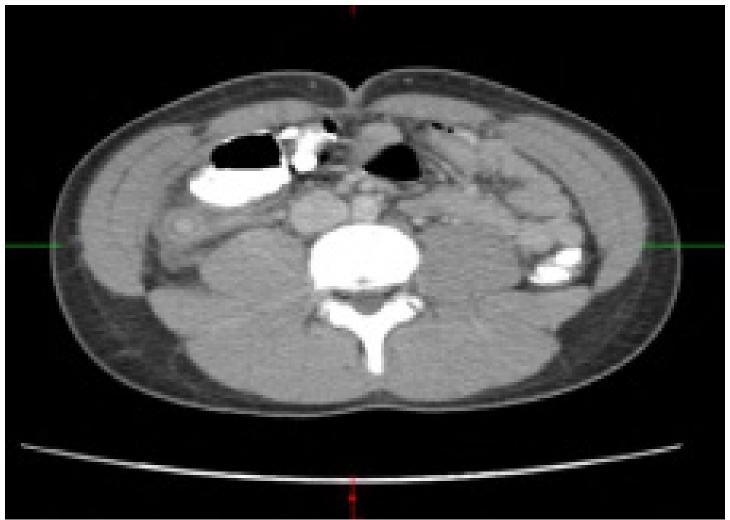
CT of abdomen and pelvis with IV Contrast -Transverse View
